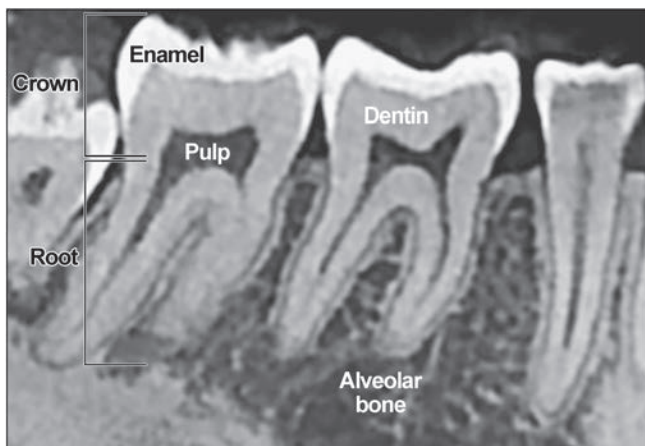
Vertical cone beam computed tomography slice of mandibular molars and premolars. (Courtesy M. Schmittbuhl.)
